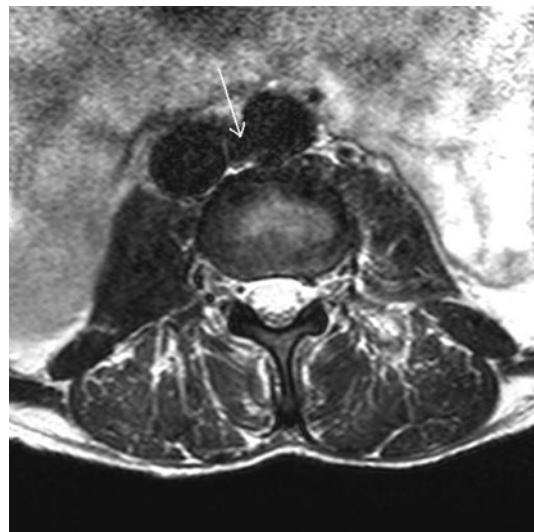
Abdominal magnetic resonance imaging (MRI) at L3 shows the aortocaval fistula (ACF) as a communication (arrow) between the aorta (Ao) on the left and inferior vena cava (IVC) on the right
